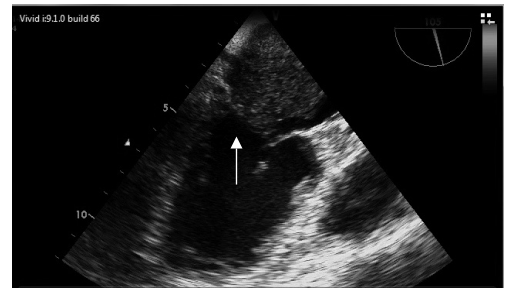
Transesophageal echocardiography showing cardiac myxoma prolapse into the mitral valve (arrow)
